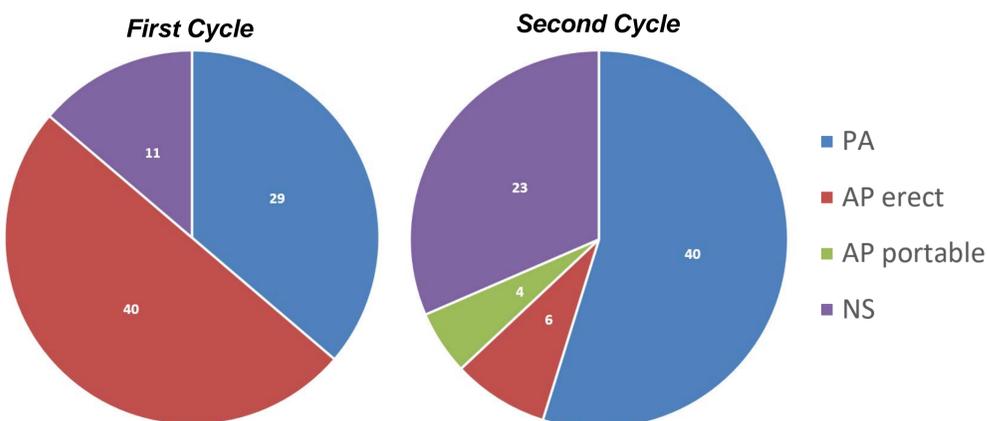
Pie charts of numbers of chest radiographs performed in first and second cycles of audit. PA = posteroanterior, AP = anteroposterior, NS = non-specified
